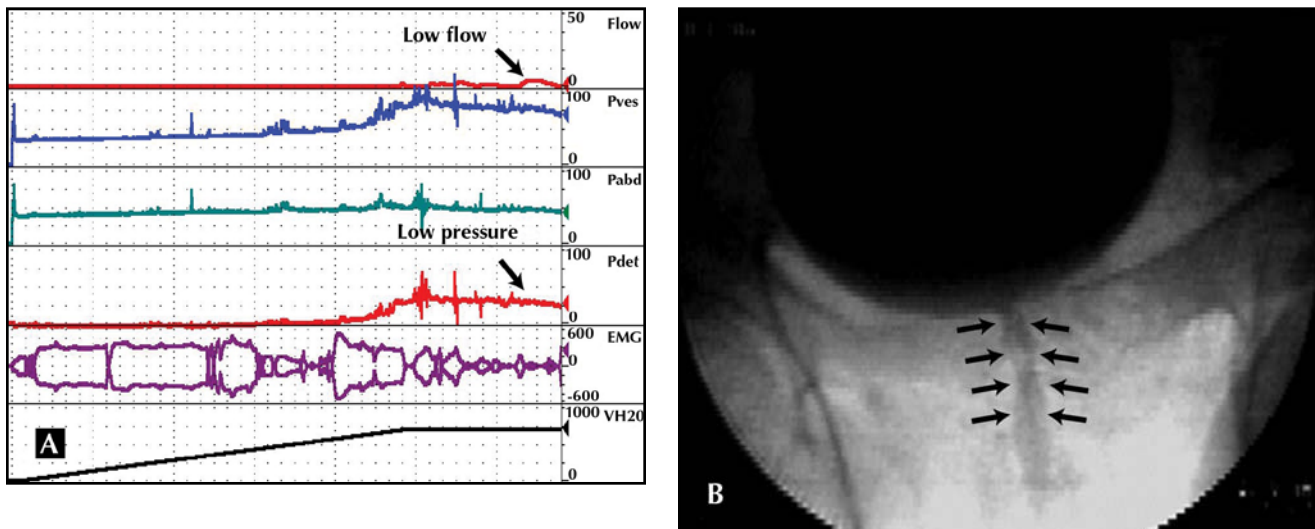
A, Impaired detrusor contractility in a 58-year-old man who complains of severe LUTS (urinary frequency, urgency, occasional urge incontinence, hesitancy, and weak stream). B, Urodynamic tracing. Despite the history of urge incontinence, there were not any involuntary detrusor contractions at cystometry. This is termed type-1 overactive bladder [18••]. Unexpectedly, the patient had a large bladder capacity (710 mL). When asked to void, he had a sustained detrusor contraction and a low flow ($Q_{\max} = 6 \text{ mL/sec}$, $P_{\text{det } Q_{\max}} = 28 \text{ cm H}_2\text{O}$). This corresponds to a very weak bladder and no obstruction on the Schaefer nomogram. Radiograph obtained at Q_{\max} shows a narrowed prostatic urethra (arrows). Of note, if urodynamics were not performed, this patient would have been erroneously diagnosed as having prostatic obstruction because of his low uroflow. EMG—electromyogram; LUTS—lower urinary tract symptoms; Pabd—abdominal pressure; P_{det} —detrusor pressure; Pves—vesical pressure; Q_{\max} —maximum urinary flow; $V_{\text{H}_2\text{O}}$ —infused bladder volume. (Courtesy of Jerry G. Blaivas, MD.)
